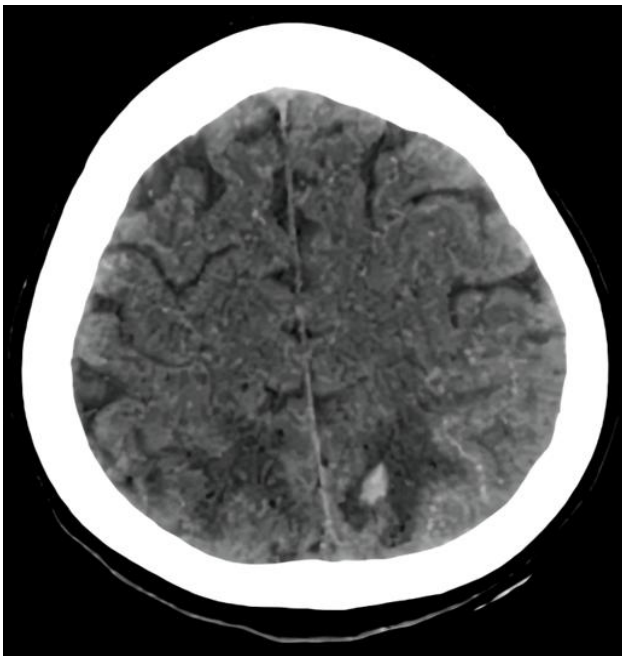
Axial computed tomography of the brain showing symmetrical hypodensities of the white matter over bilateral parieto-occipital areas, consistent with vasogenic edema (hyperdensity over left parieto-occipital region, indicating intraparenchymal and subarachnoid hemorrhage) (Reprinted with permission of the patient)
